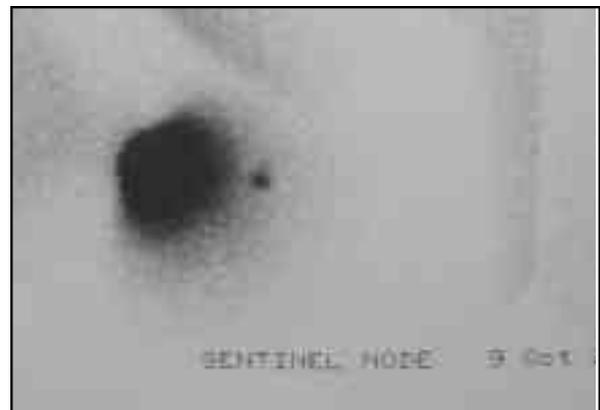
The sentinel node on lymphoscintigraphy
